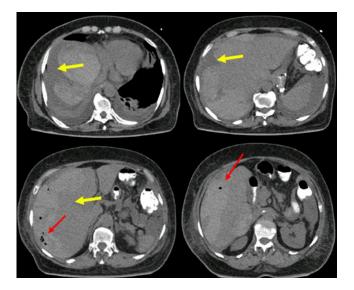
Contrast-enhanced CT of the abdomen. 206×150×70 subcapsular hematoma of the liver; volume: 1168 cc (yellow arrow), with free fluid in the cavity and presence of pneumobilia (red arrow).
